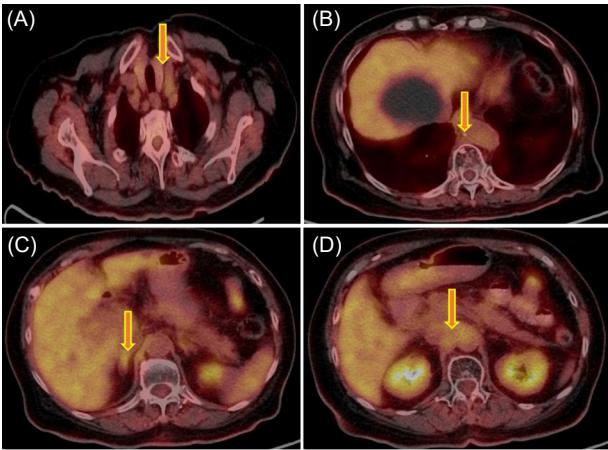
Post-treatment PET/CT imaging.
